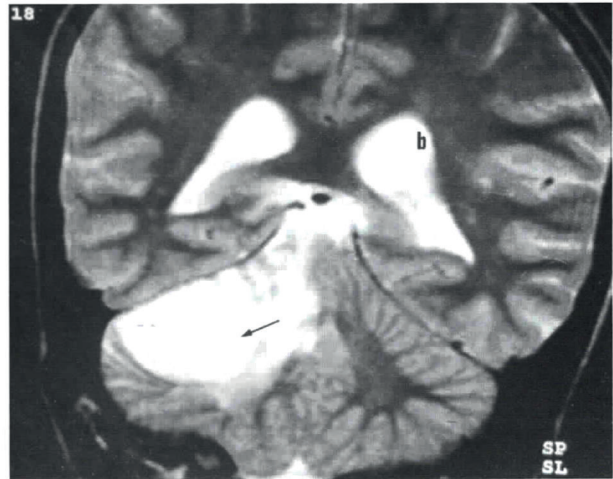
a) T1 weighted axial MRI scan shows an otogenic brain abscess in the cerebello-pontine angle. The capsule enhances markedly with the contrast, b) In T2 weighted coronal images, peripheral edema and necrotic center of abscess are seen hyperintense compared to gray matter. Between the zone of edema and necrotic center, the capsule can be visualized (arrow), c) CT scans with contrast shows that the abscess cavity and capsule have completely disappeared after single burr-hole aspiration.
